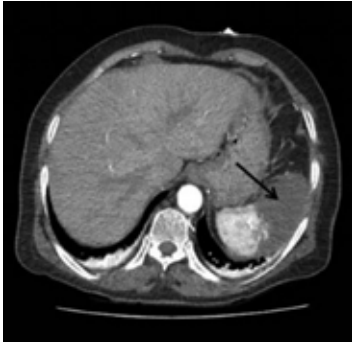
The infarct area greater than 50% of spleen is seen in axial plane CT angiography (arrow).
